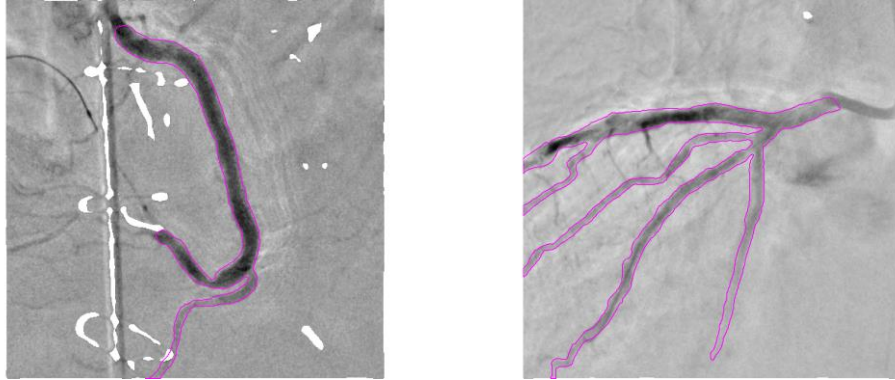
Manual masks (colour lines) on images after background subtraction for X-ray 1 (left) and X-ray 2 (right). The manual masks for the remaining X-rays are presented in Appendix F.
